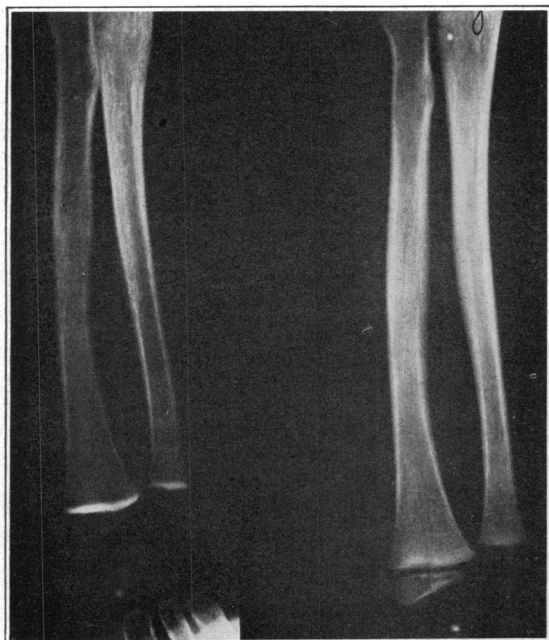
Case 2. Note the dense lines at the epiphyses of the radius and ulna, on the left; normal x-ray of child same age on right for comparison.
